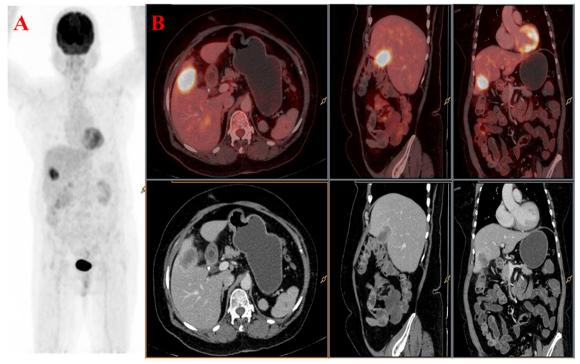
18F FDG PET/CT scan of patient a 63-year-old women was having right hypochondriac pain, neuroendocrine carcinoma stage pT2a, G3 grade and positive on PET/CT A, Maximum intensity projection image (MIP) shows abnormal focal area of FDG avidity in segment V of right hepatic lobe, B, PET/CT and corresponding CT show FDG avid liver infiltration
